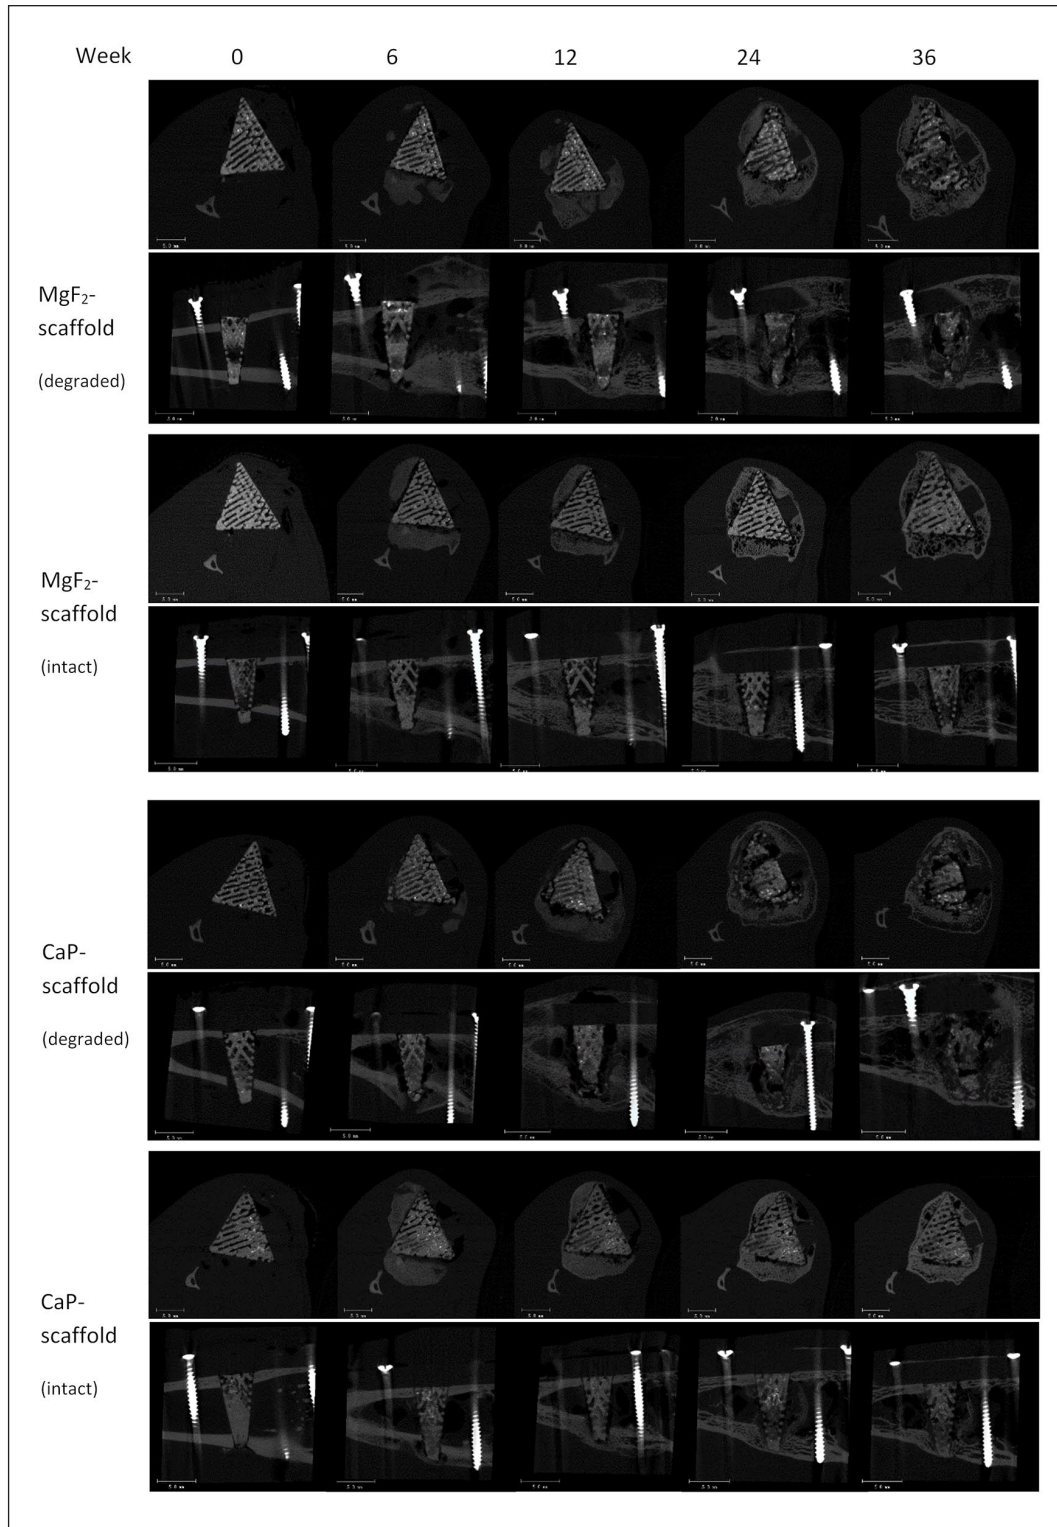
μ CT images of the center of intact and severely degraded scaffolds in the original and the reoriented scan.
